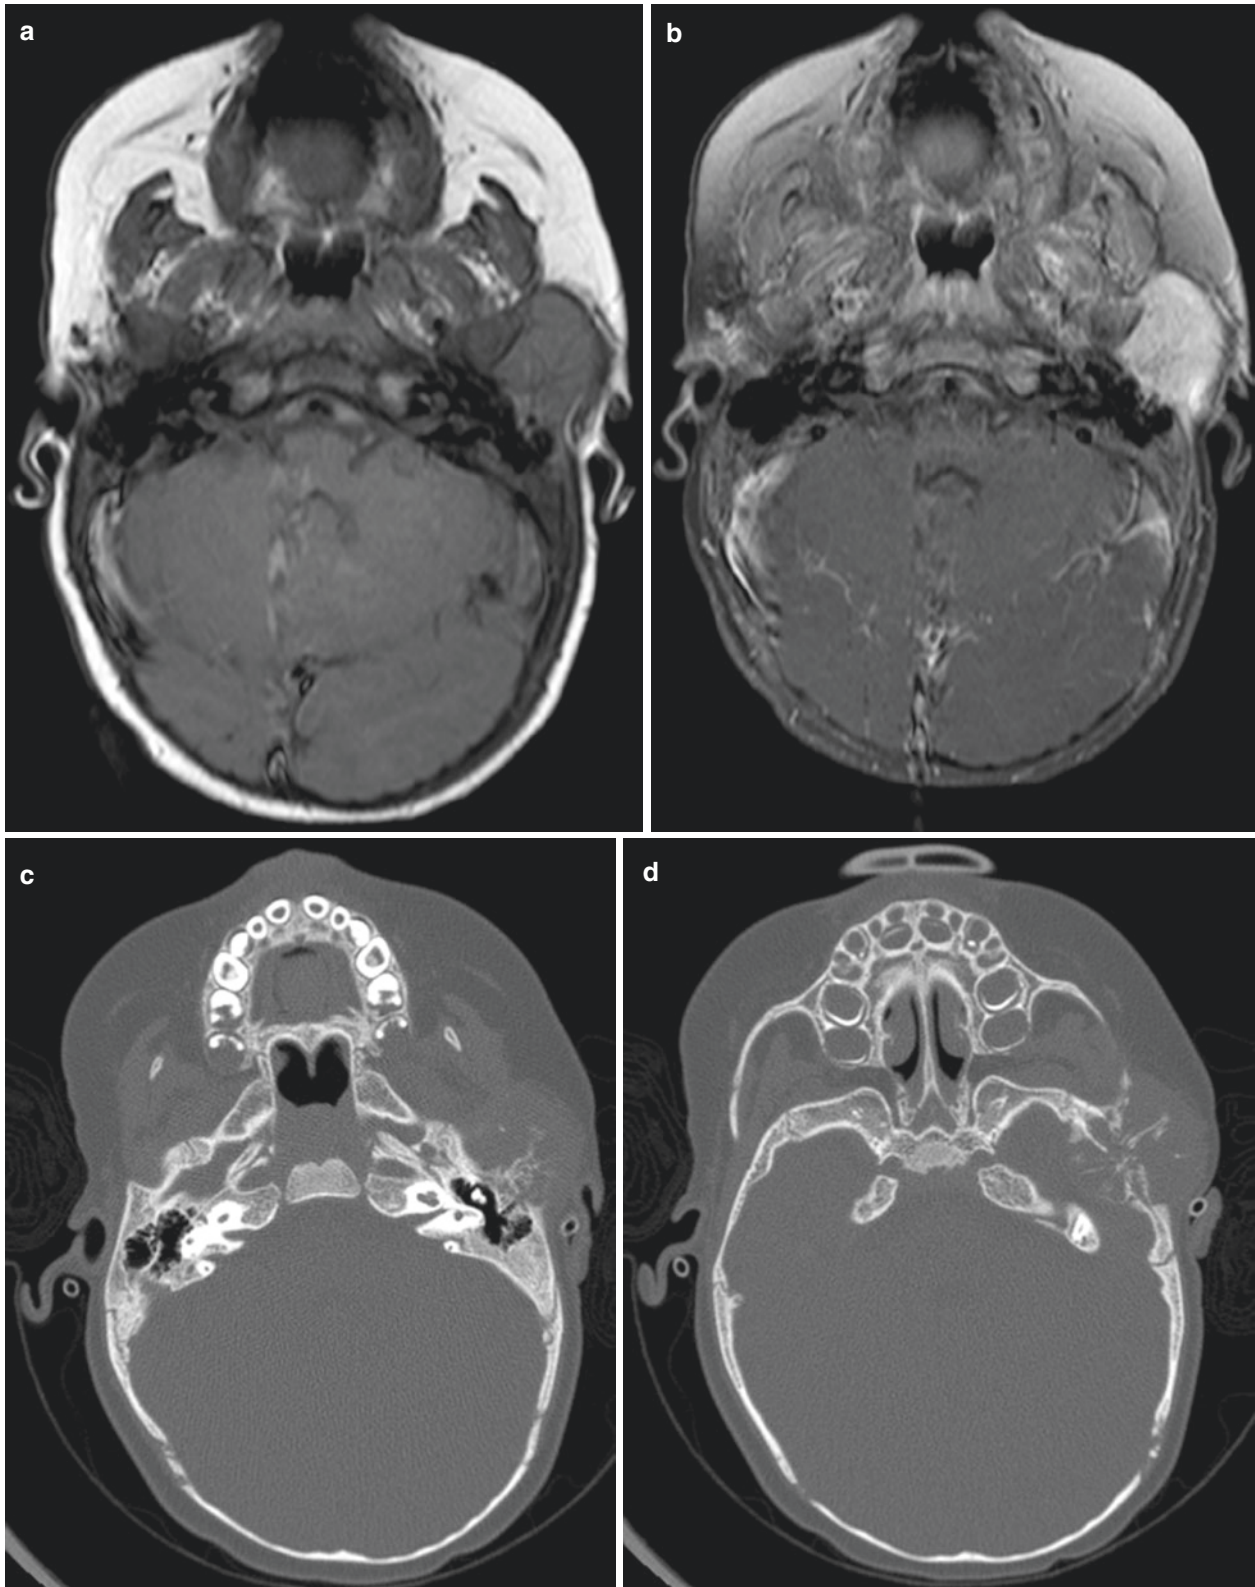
(a) Axial T1 MRI of Ewing sarcoma. MRI can be valuable to delineate the extent of adjacent soft tissue involvement, particularly to assess for dural invasion. (b) Axial T1 MRI with gadolinium of Ewing sarcoma. MRI can be valuable to delineate the extent of adjacent soft tissue involvement, particularly to assess for dural invasion. (c) Axial CT in Ewing sarcoma forms radiolucent osteolytic lesions that
